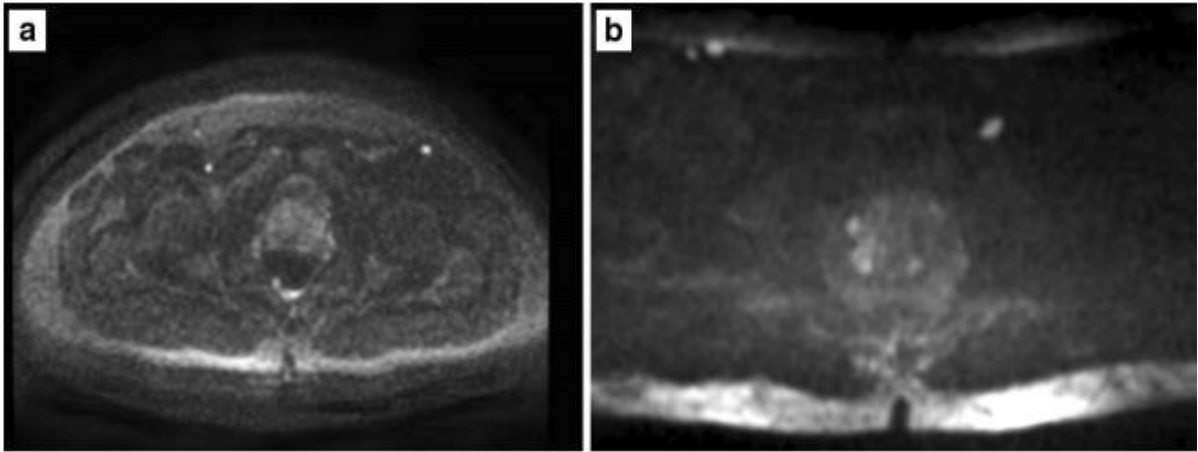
DWI of suboptimal (38x40cm) (a) and optimal (17x20cm)(b) field of view according to the PI-RADS v.2.1 guidelines (9)
